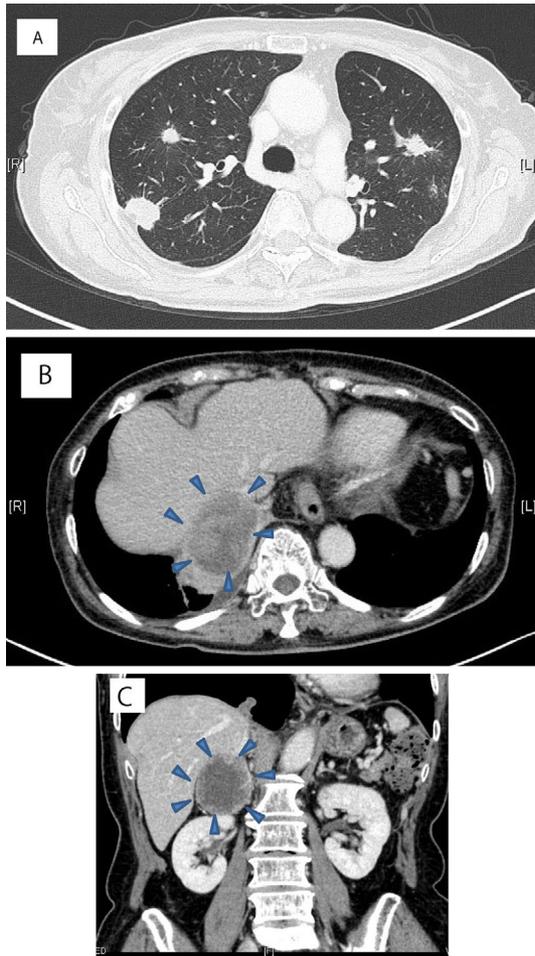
Computed tomography (CT) scans obtained in 2010. (A) A chest CT scan revealed intrapulmonary metastases in both lungs. (B, C) An abdominal CT scan revealed a huge right adrenal metastasis (arrowheads).
